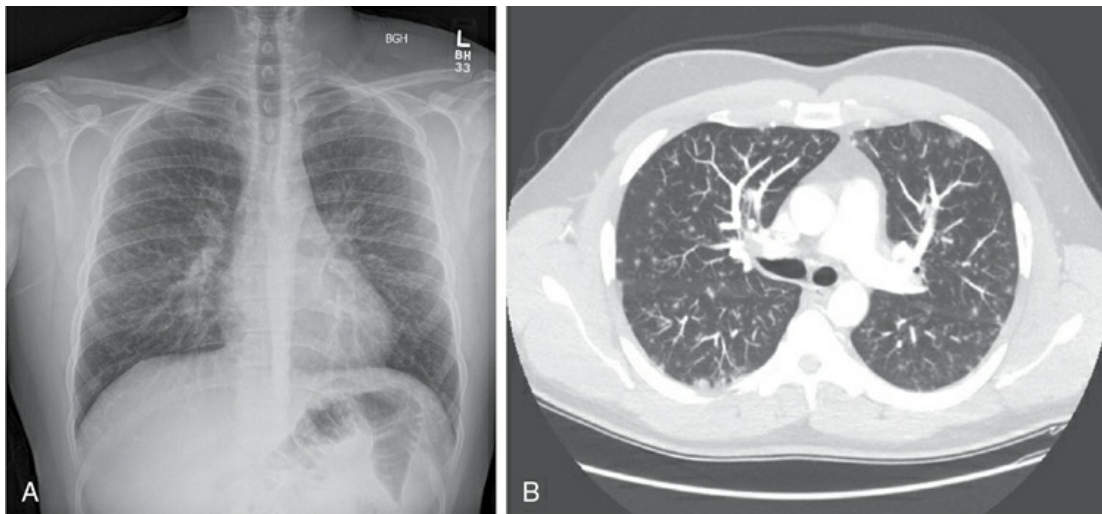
Posteroanterior chest radiograph (A) and chest CT scan (B) of a patient with *Mycoplasma pneumoniae* pneumonia. Note patchy opacities throughout both lungs. *Source:* (Courtesy of Dr. Laura Avery.)
